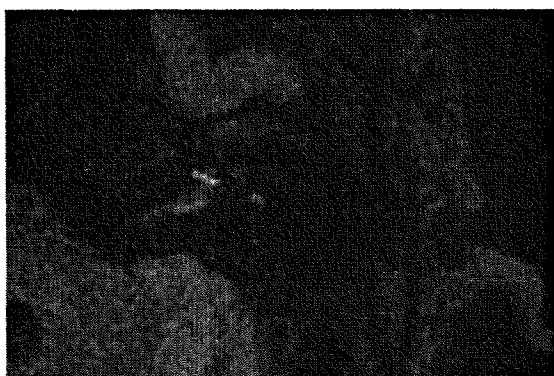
3D-FLAIR MRI in a 47-year-old man with Ménière's disease. Visualization of the semicircular canals was not obvious. Because there were extremely large endolymphatic hydrops in the vestibule, Gd movement towards the semicircular canals was disturbed.
